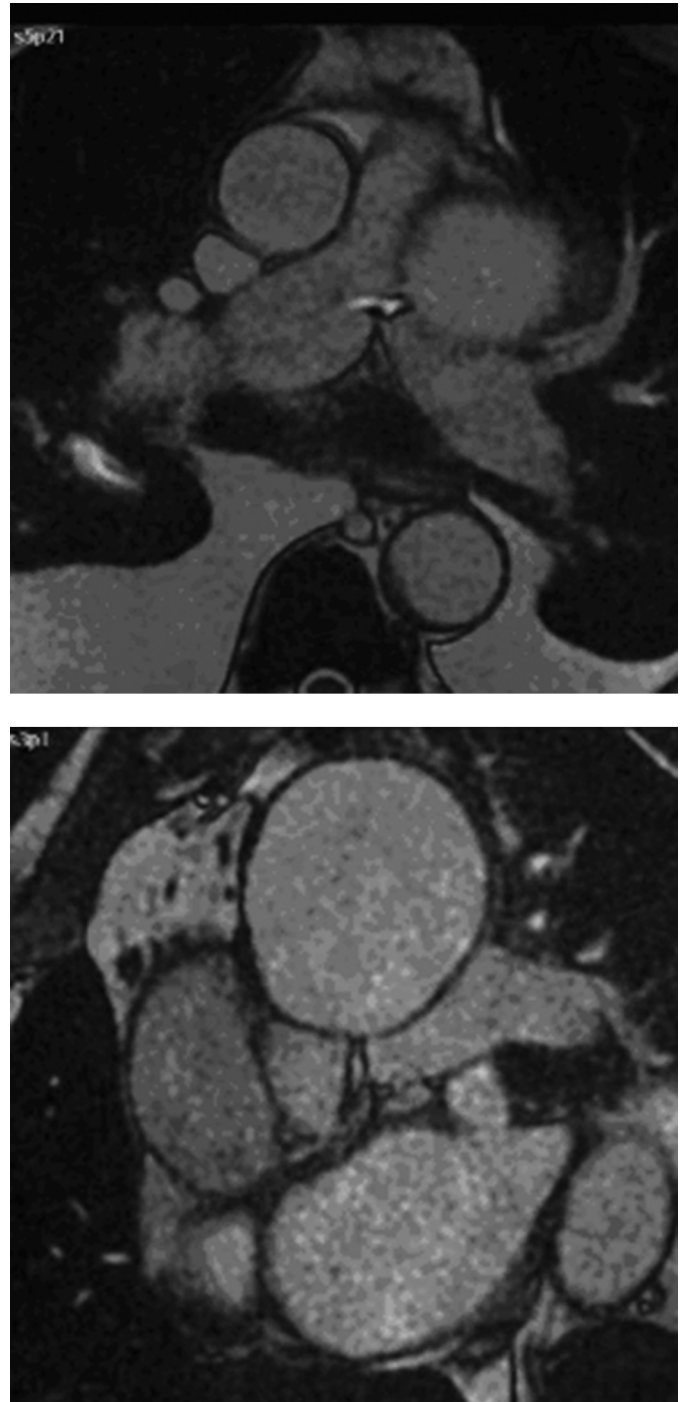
Dynamic cardiac MRI for evaluation of the aorto-pulmonary fistula using cine-steady-state-free-precession sequence at the same levels as seen on computed tomography. Note the high-velocity shunt through the fistula between the aortic arch aneurysm and the left pulmonary artery.
